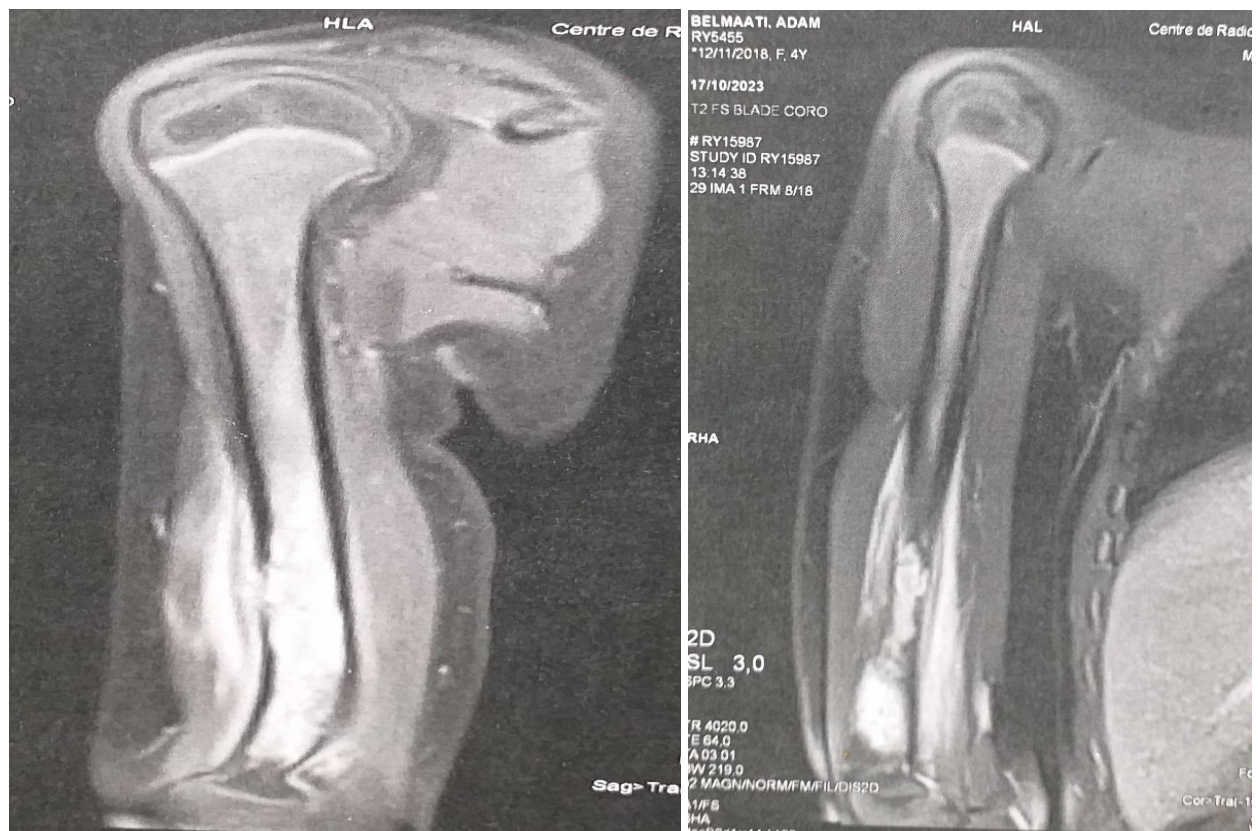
MRI image of peripheral intraductal diaphyseal lesion of the middle and lower 1/3 junction of the right humerus accompanied by a rupture of the antero -external cortex and a continued unilamillary periosteal reaction
